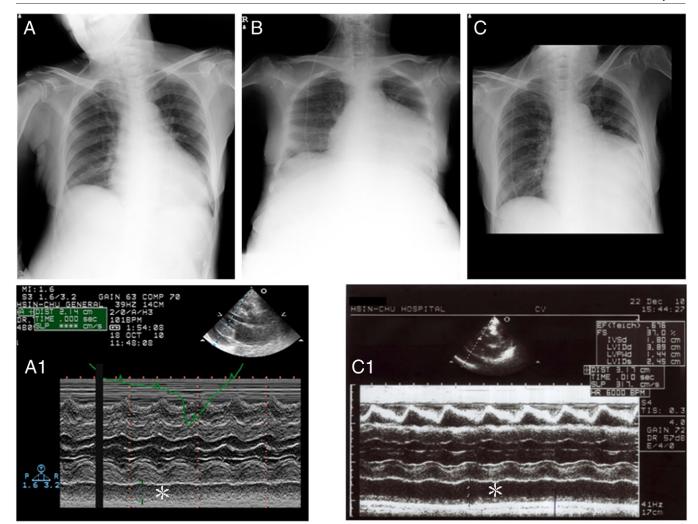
Chest x-ray films (A-C) and echocardiography (A1 and C1) showing pericardial effusion. A and A1, Four months before this admission. The thickness of the pericardial effusion was 2.1 cm (asterisk in A1). B, Chest x-ray at admission. C and C1, Day 6 on admission, right before pericardiocentesis was performed. The thickness of the pericardial effusion was 3.2 cm (asterisk in C1).
